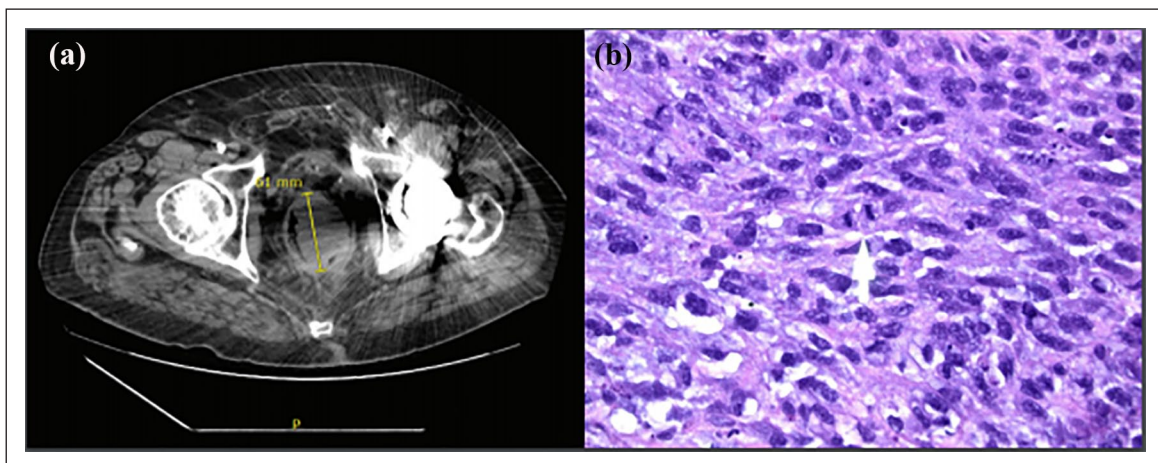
An abdominal CT showed a 6.1 cm large heterogeneous rectal mass (a) and biopsy showed a poorly differentiated malignancy with spindle cell features (b).
